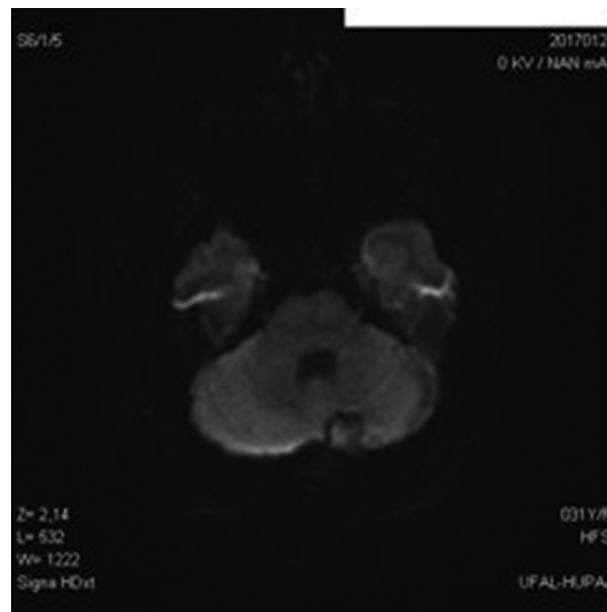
Magnetic Resonance imaging: axial cut showing (A) heterogeneous signal in the FLAIR, and (B) a hyperintense signal in the restriction, making the epidermoid cyst the main diagnostic hypothesis.
